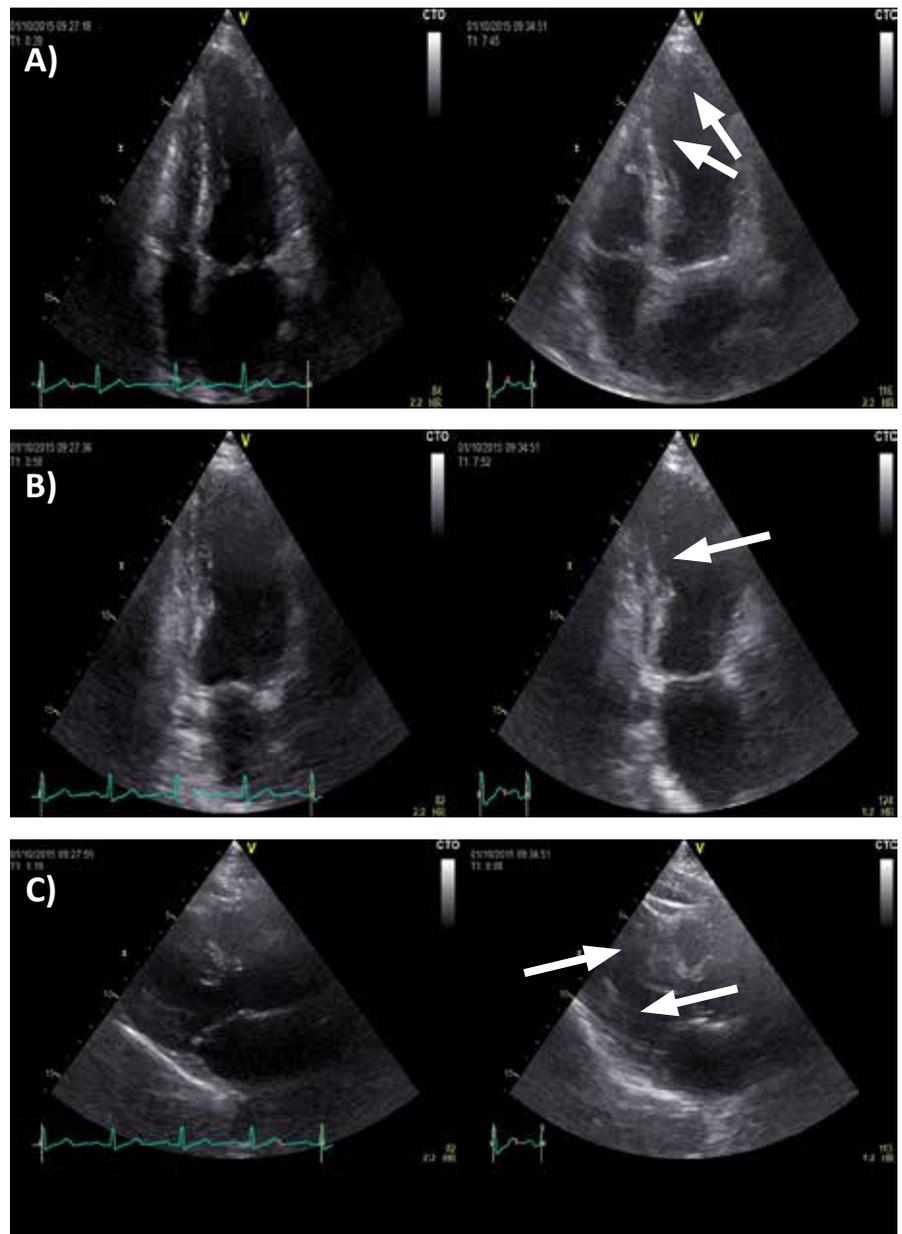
A) 4-chambers view at rest (left side) and on SECHO test (right side) B) 2-chambers view at rest (left side) and on SECHO test (right side) C) Parasternal long axis view at rest (left side) and on SECHO test (right side); arrows showing wall motion abnormalities
